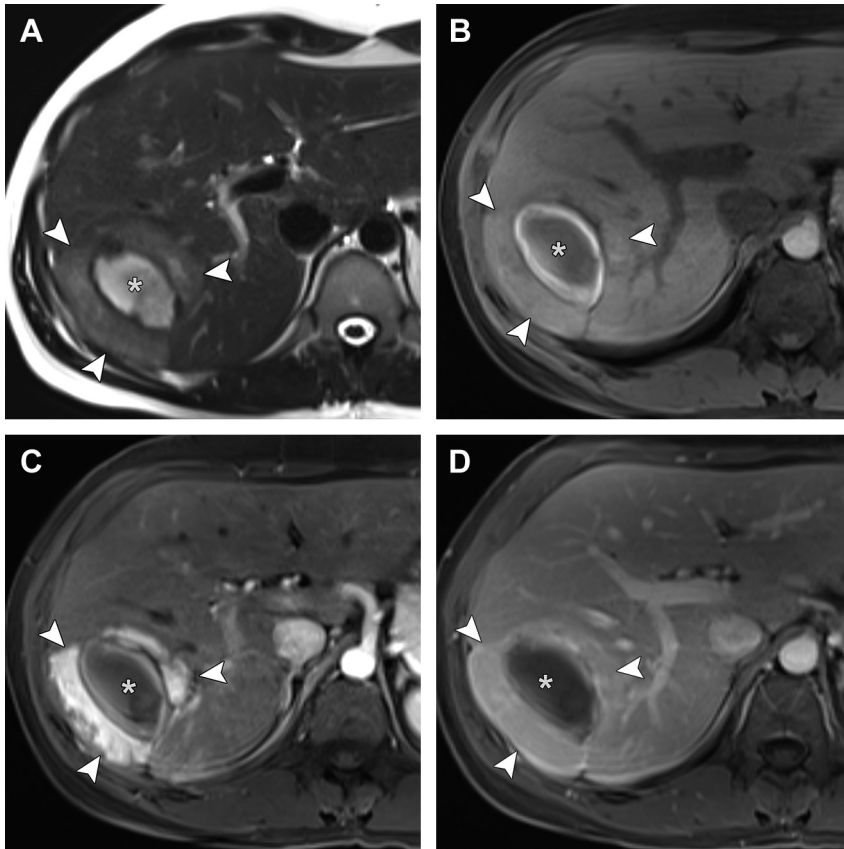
HCA complicated by hemorrhage (inflammatory subtype). (A) Slightly T2 hyperintense mass (arrowheads) in the posterior right lobe contains a central ovoid region of bright signal surrounded by a thin T2 hypointense rim (asterisk). (B) The mass itself is isointense to liver on T1-weighted fat-suppressed images (arrowheads), whereas the central region is partially T1 hyperintense compatible with blood products (asterisk). (C, D) Postcontrast images demonstrate strong arterial hyperenhancement of the mass (arrowheads) that persists on delayed images without washout. The central region does not enhance, in keeping with hemorrhage (asterisk). Surgical pathology revealed inflammatory HCA, which is suggested by its T2 signal intensity and enhancement pattern; inflammatory HCA is the subtype most prone to hemorrhage.
